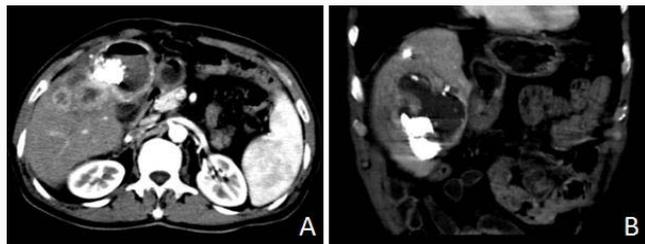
Liver abscess after TACE in an old patient with rHCC and diabetes. (A) Contrast-enhanced transverse CT imaging obtained 3 weeks after TACE shows multiple intrahepatic abscess (ring-enhancement) formation with gas fluid level; (B) coronal CT imaging in the same patient.
